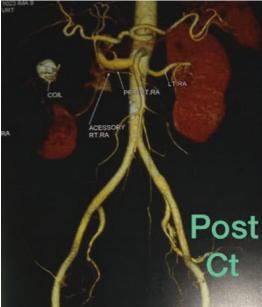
Post-AVM embolisation CT angiography confirms total occlusion of renal AVM
